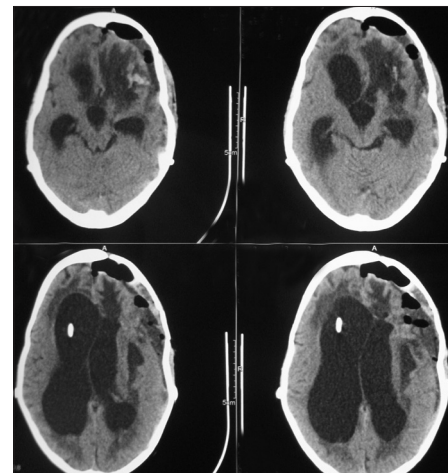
CT scan showing hydrocephalus less than before however porencephalic cyst has completely disappeared and SDH has decreased in volume
